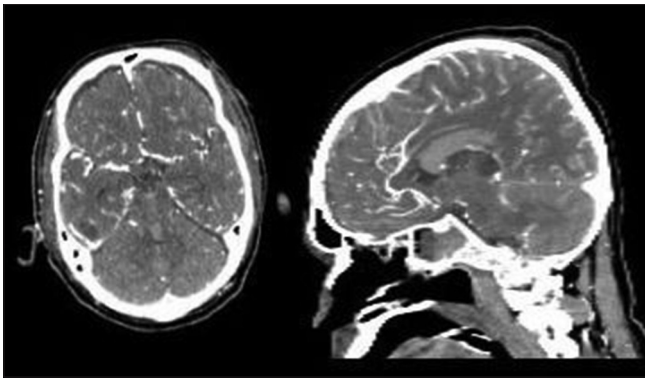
Computed tomography angiogram of brain showing normal vasculature
